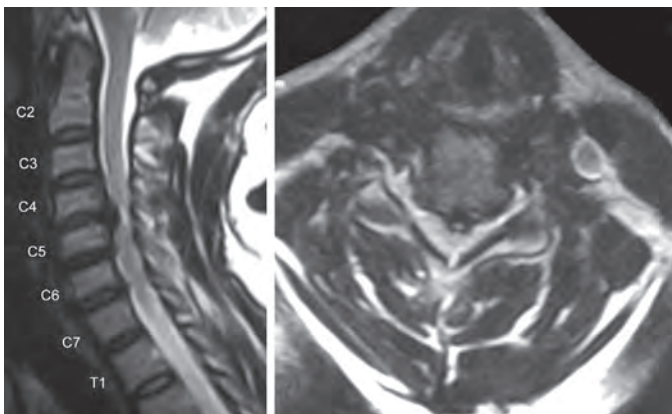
MRI cervical spine showing C4-5 central disc prolapse with increased signal intensity in T2 images
